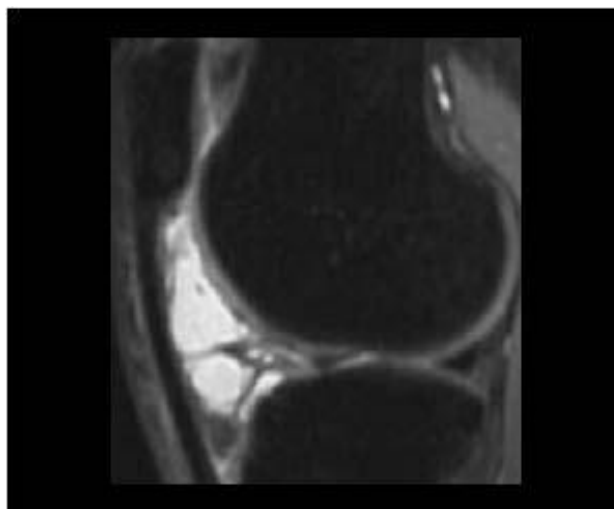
Knee joint Synovial cyst, Sagittal T2 weighted Magnetic Resonance Imaging (MRI)
